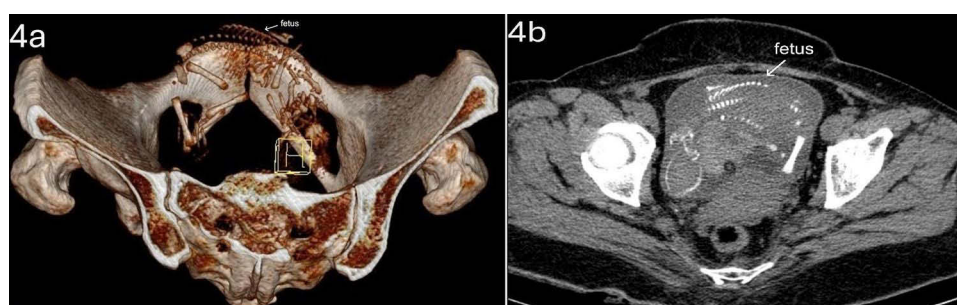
Abdominal CT scan showed that there was a fetal skeleton in the bladder: (a) 3D CT scan imaging of the pelvic region; (b) Axial CT scan of the pelvic region.
